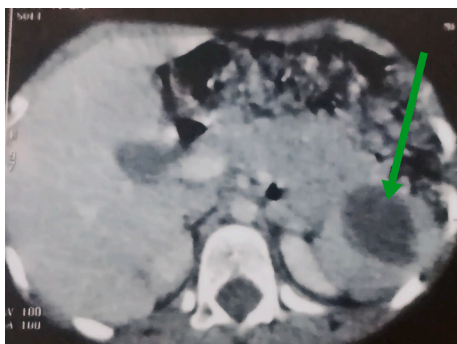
CT/cross axial view showing an isolated cyst formation in the spleen in the peripheral part (green arrow) of it and far from the navel of the spleen, without calcifications.
